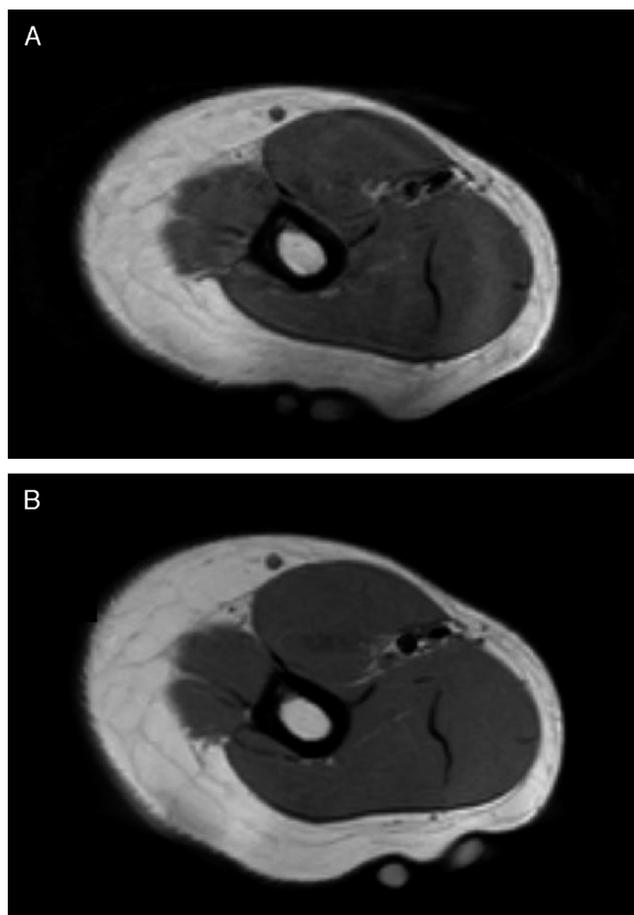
Typical magnetic resonance images showing transverse sections of the trained upper arm taken before (A) and after (B) the 10-wk training.
